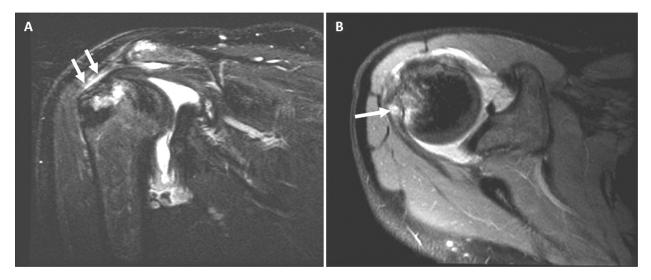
MRI of a humeral head Hill-Sachs lesion. A) Coronal-oblique view. B) Axial view.
